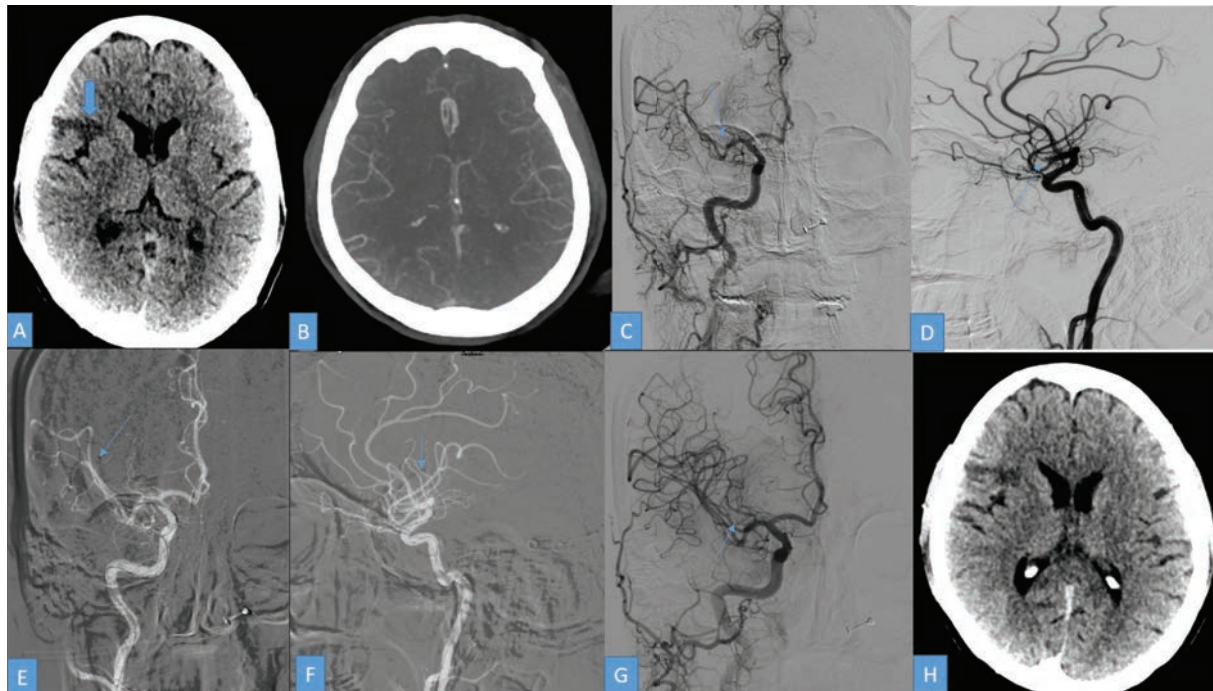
A 42-year patient, a known case of rheumatic heart disease with mitral valve stenosis, presented with acute onset left side weakness and facial deviation for 2 hours. On examinations, her NIHSS was 8 and E4V5M6. IV thrombolysis (rTPA) was given. ASPECTS score was 9 and the collateral was good. On CT angiography there was a cut-off noted in the right M2 MCA superior division. After proper written consent, a mechanical thrombectomy was performed under local anaesthesia.
